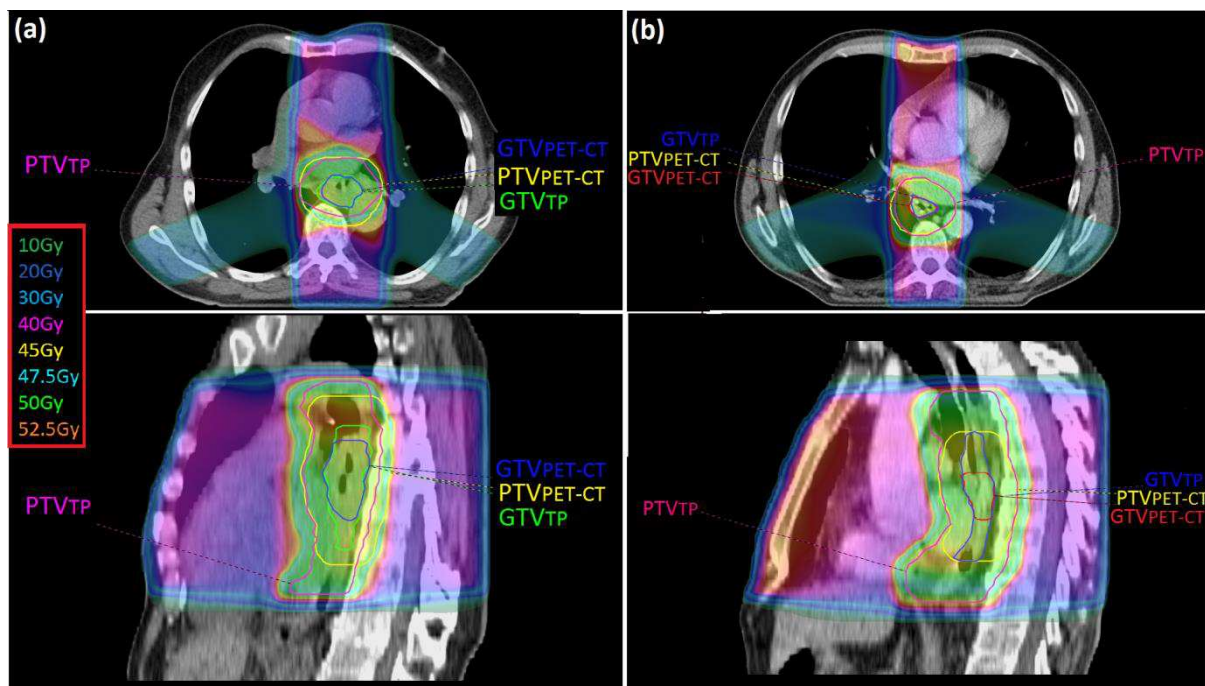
Examples of the location of GTV_{TP} , PTV_{TP} , GTV_{PET-CT} and PTV_{PET-CT} relative to the high dose region; (a) For patient 3, the PTV_{PET-CT} extends posteriorly compared to PTV_{TP} but is still contained within the high dose region (b) For patient 5, both the GTV_{PET-CT} and PTV_{PET-CT} are contained within the high dose region.
